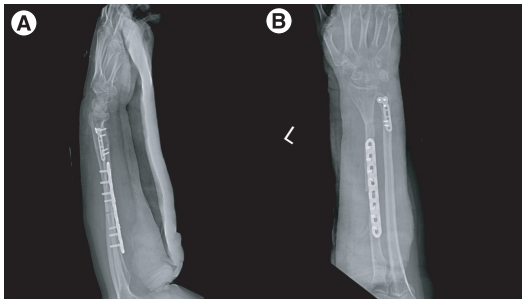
Lateral and anteroposterior radiographs of the patient after fixation with plates and screws.
